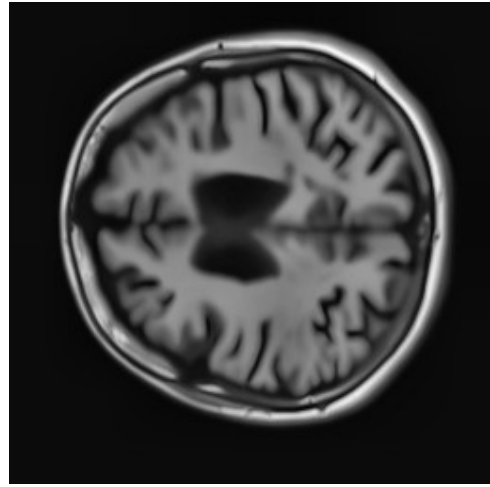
One of the FLAIR-MRI Images With MS Lesions of Patient 3*
